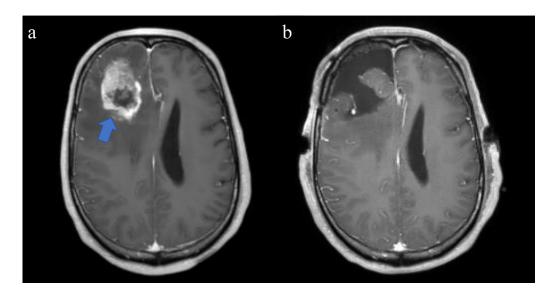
MRI before and after the first surgery. (A) A ring-enhanced lesion on the right frontal lobe is visible on preoperative MRI (arrow). (B) No apparent residual tumor as seen on postoperative MRI.
